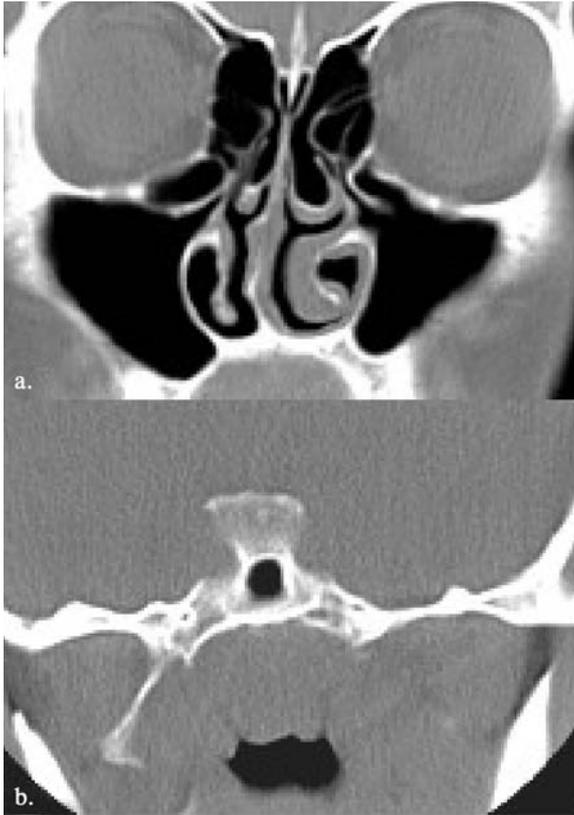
1a) Coronal Paranasal CT image shows prominent nasal mucosal thickening and inferior turbinate hypertrophy located in the opposite side of the deviation without sinusitis.
